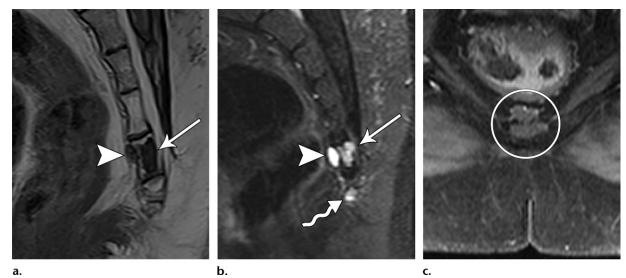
Chordoma in a 30-year-old man with a history of lymphoma who reported coccyx pain. Sagittal T1-weighted (a), sagittal STIR (b), and axial contrast-enhanced T1-weighted fat-suppressed (c) images show a region of fluid signal intensity in the first coccygeal body (straight arrow) that extends anterior to the bone (arrowhead) but does not enhance (circle). These imaging features were interpreted initially as a fracture. However, the well-defined peripheral rim of preserved marrow fat signal intensity and the lobular mass present anteriorly are suggestive of a different cause. This proved to be a chordoma at biopsy. A focus of fluid signal intensity (wavy arrow) is also present at the tip of the coccyx, likely representing a second focus of chordoma.
